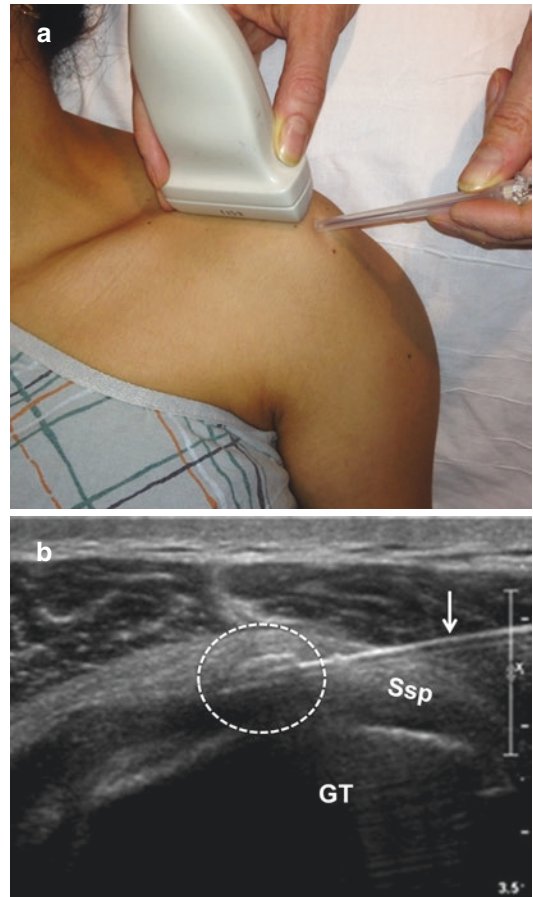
(a) Patient positioning and needle placement. (b) Ultrasound image demonstrates optimal needle placement (arrow) with the needle tip at the center of the calcific deposit (circle). *Ssp* supraspinatus tendon, *GT* greater tuberosity
